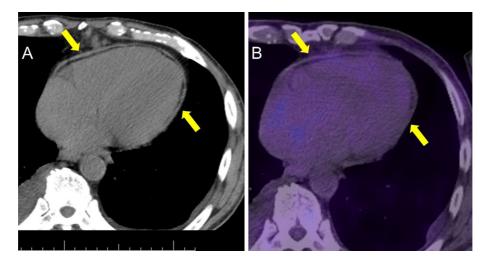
(A) CT scan of the heart demonstrating the significantly thickened pericardium (5 mm) (yellow arrows) with no pericardial calcification. (B) FDG positron emission tomography revealing no abnormal FDG uptake in the pericardium (yellow arrows).
